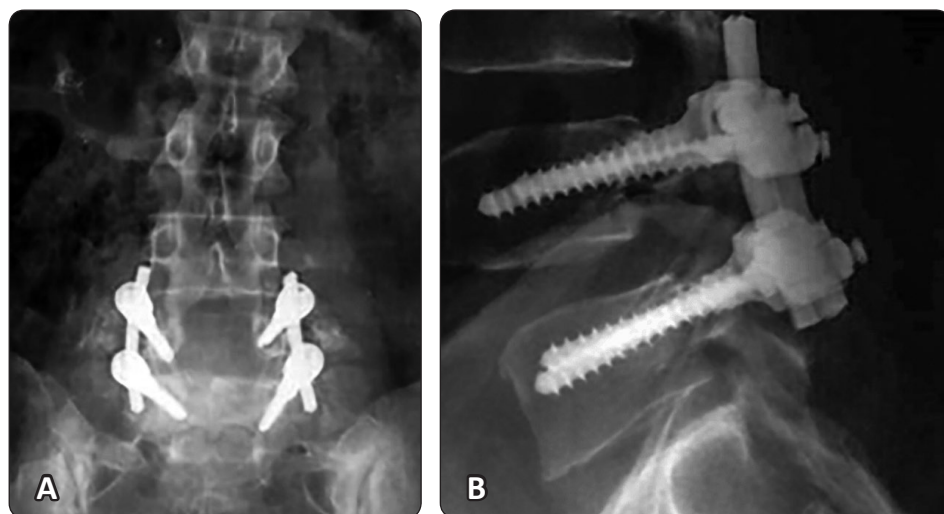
Plain radiographs lumbar spine (A) AP and (B) Lateral at final follow up showing spondylolisthesis L4-5 treated by wide neural decompression, posterolateral fusion and transpedicular screws fixation.
